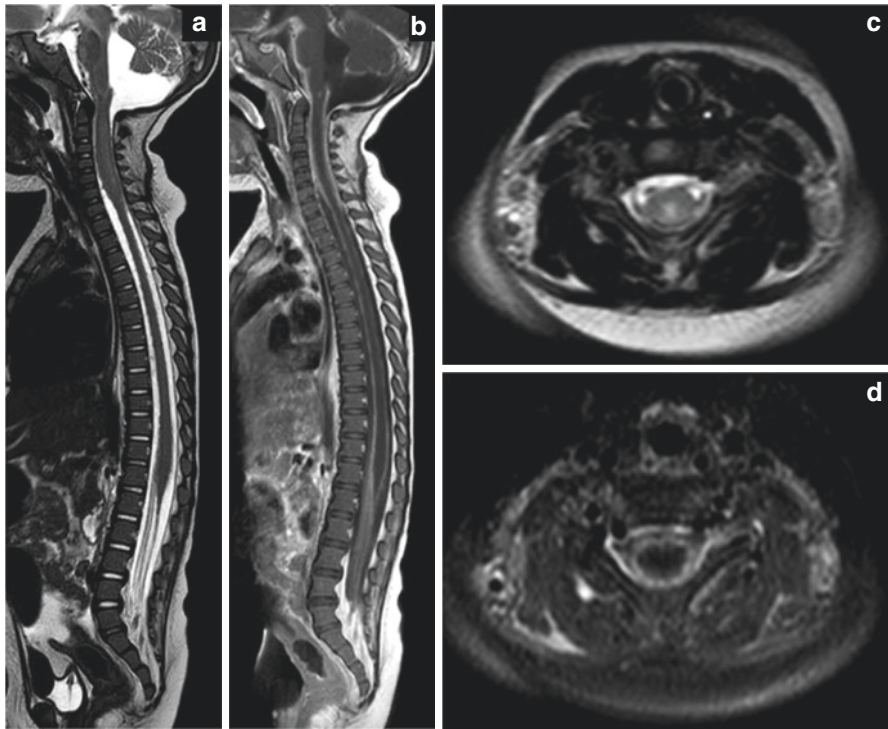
MR appearance of Tuberculous leptomenigitis: T2-weighted (a) and GD-enhanced T1-weighted (b) spine images on the sagittal plane; T2-weighted (c) and GD-enhanced Fat-suppressed T1-weighted (d) spine images on the axial plane at cervical level. Diffuse leptomenigeal thickening and enhancement of the surface of the spinal cord and nerve roots, due to inflammatory cells infiltration of the arachnoid is evident. The cervical medulla is more involved, where swelling, intramedullary edema and exudate is observed in the proximal tract of the central canal (*). Images also show thick basal leptomenigitis, with secondary obstructive dilation of the posterior fossa cisterns and fourth ventricle
